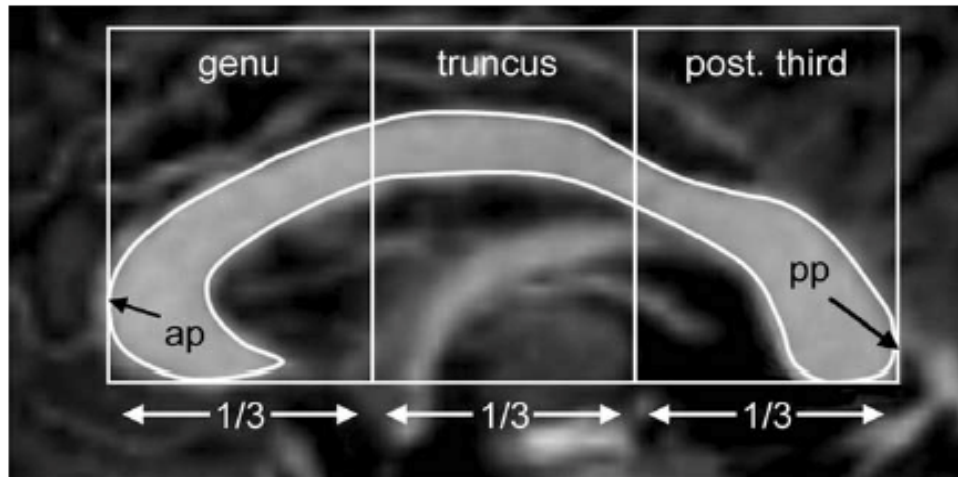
Westerhausen et al.'s 3-part CC segmentation method. Reprinted from "Effects of handedness and gender on macro- and microstructure of the corpus callosum and its sub-regions: a combined high-resolution and diffusion-tensor MRI study," by Westerhausen et al., 2004, *Cognitive Brain Research*, 21, p. 420. Copyright 2004 by Elsevier B. V. Adapted with permission.
